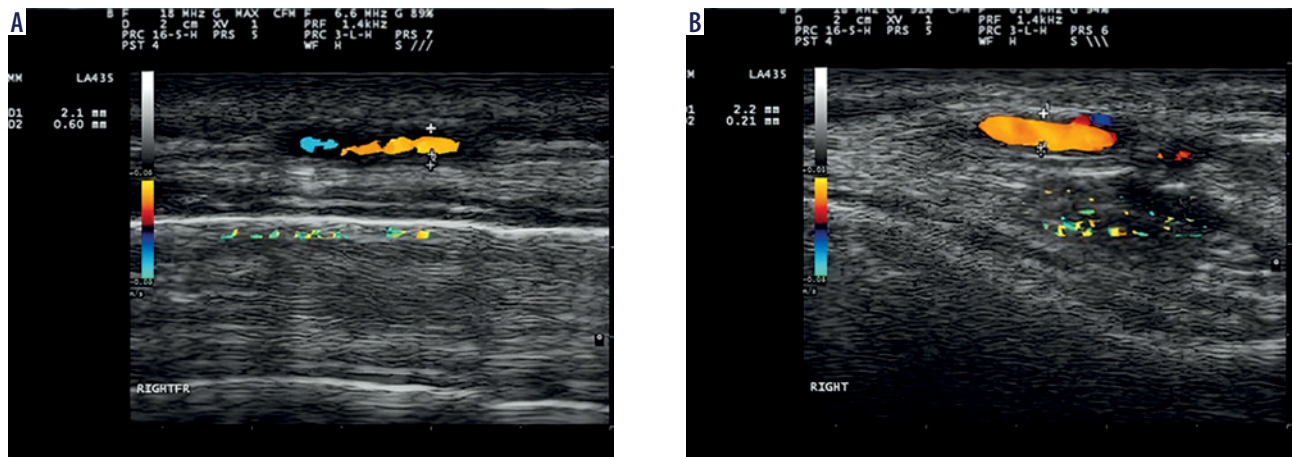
Color doppler imaging results in patient with giant cell arteritis (A) at baseline, and (B) 1 month after the first cycle of intravenous steroid treatment
